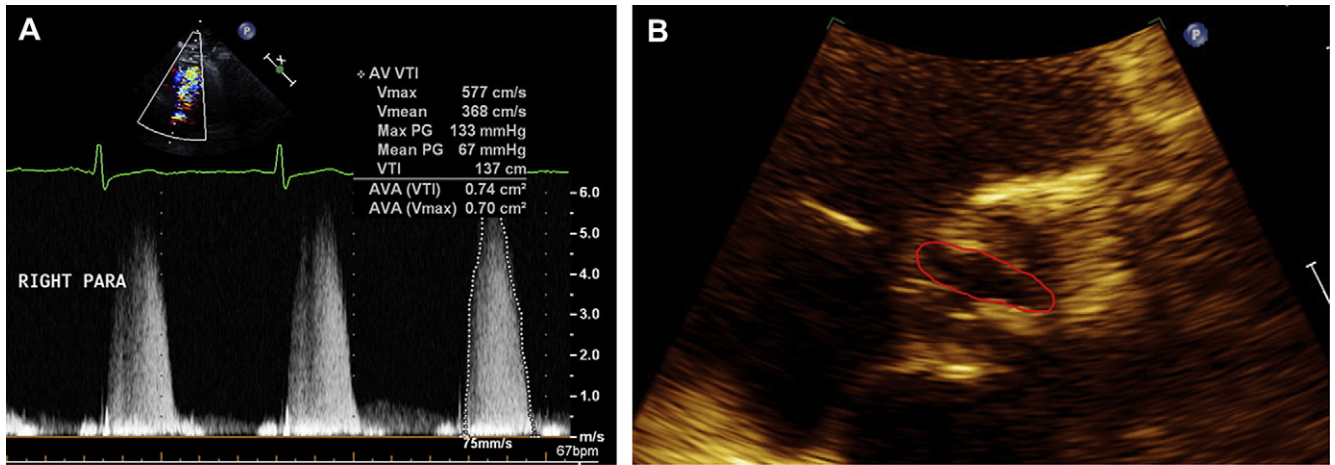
Transthoracic echocardiogram. (A) Continuous wave Doppler from the left ventricular outflow tract shows a maximal velocity of 5.7 m/s, equivalent to a peak gradient of 133 mm Hg and a mean gradient of 67 mm Hg. (B) Aortic valve planimetry with an area of 1.2 cm².
